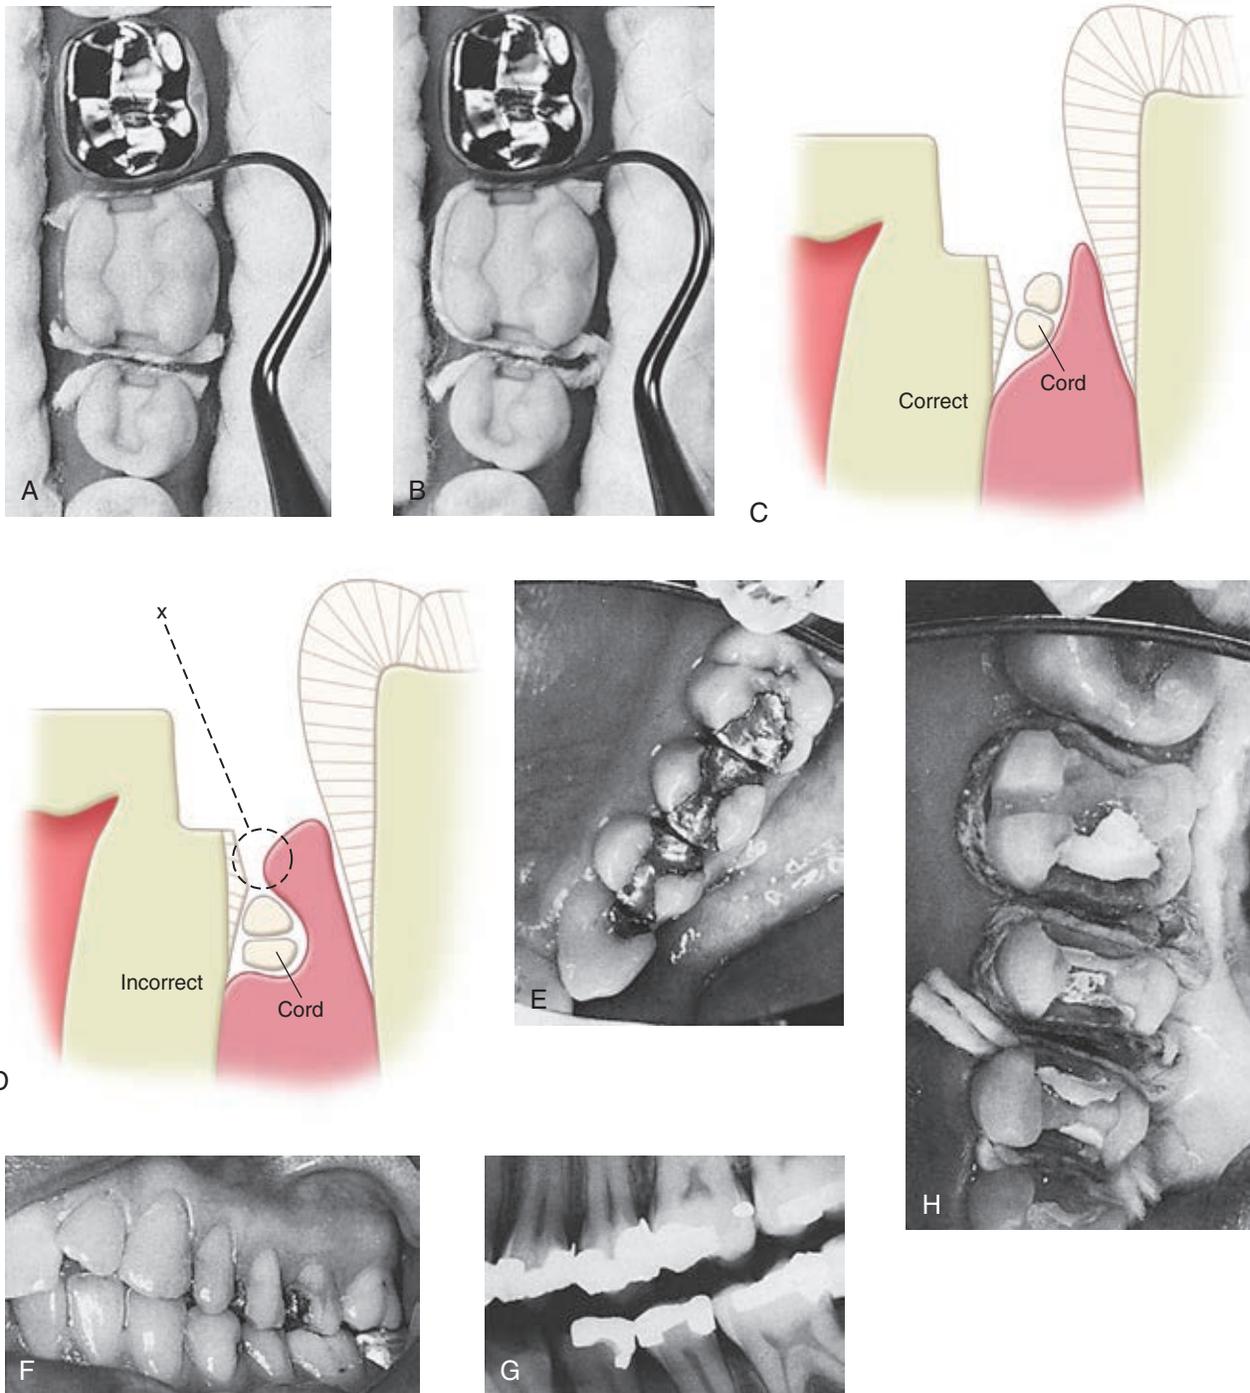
A and B, Inserting the retraction cord to widen the gingival sulcus to expose the gingival margin. Separate lengths of cord can be inserted (one for each gingival margin) (A), or a cord long enough to run from one gingival margin to another can be inserted (B). Where the margin is not subgingival, as on the lingual surface of the molar, the cord should not be in the sulcus. C, Correct application of the retraction cord. D, Incorrect application of the retraction cord causing the impression material to tear at *x*. E, Maxillary quadrant before preparing teeth for onlays. Note the fracture of the mesiofacial cusp of the molar. F, Facial view of E. G, Bitewing radiograph of E. H, Teeth prepared for onlays and ready for making the final impression. The lingual and distofacial transitional line angles of premolars are prepared for skirting.
